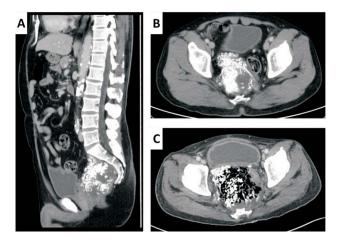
Mucinous cancer (Patient No. 8). (A) Contrast-enhanced computed tomography obtained during the venous phase shows a $10 \text{ cm} \times 9 \text{ cm}$ presacral mass with irregular contour and course calcifications. (B) An axial view of the tumor demonstrating the tumor adhering to the rectum in the pelvis. (C) The tumor's focal degeneration was also observed.
